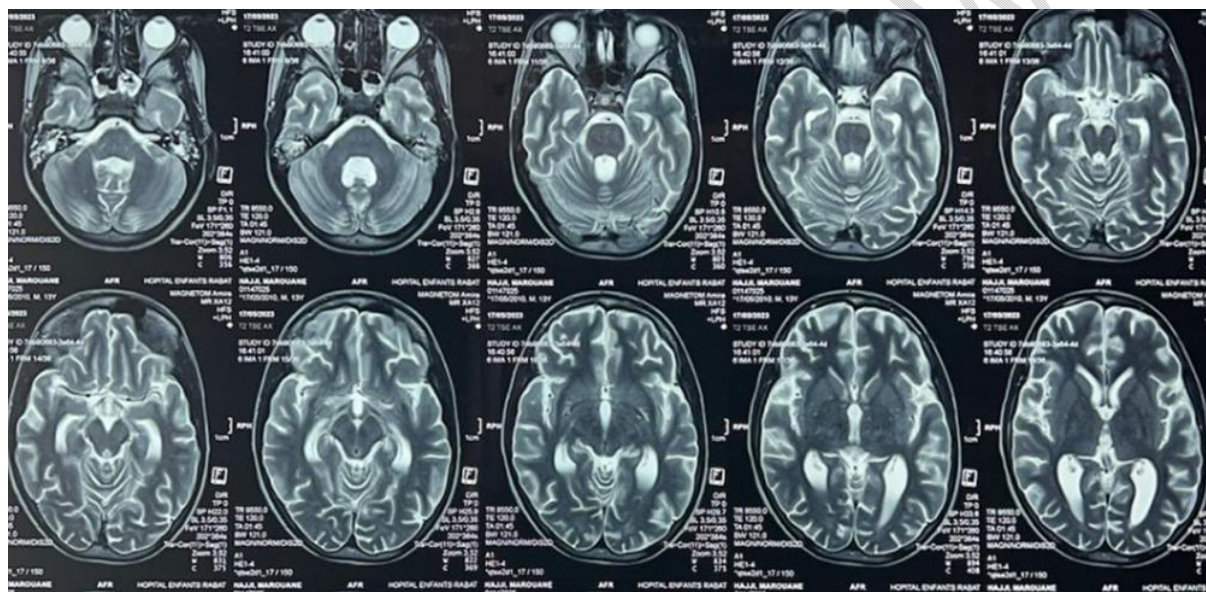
A transverse MRI scan of the brain reveals bilateral demyelinating lesions in the frontal, parietal, and cerebellar regions.
